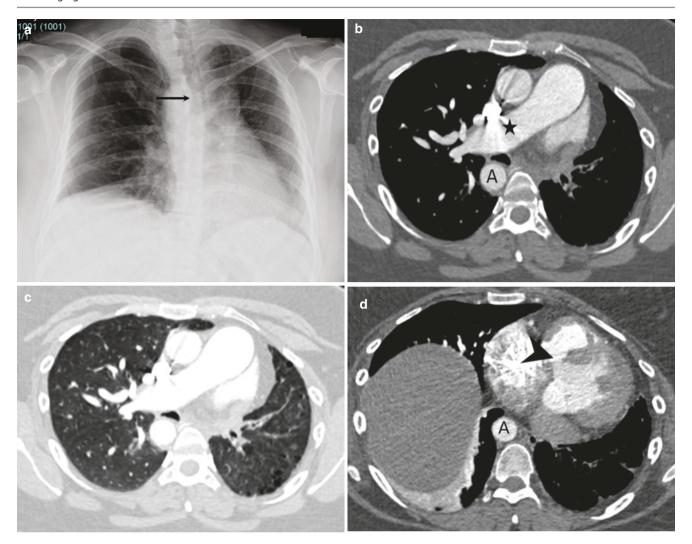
Absent left pulmonary artery in a 27-year-old woman. (a) Frontal chest radiograph shows volume loss in left hemithorax with a leftward shift of mediastinum. Note the right aortic arch indenting the right lateral wall (black arrow) of the trachea. (b) Axial CT image shows a continuation of main pulmonary as a right pulmonary artery
